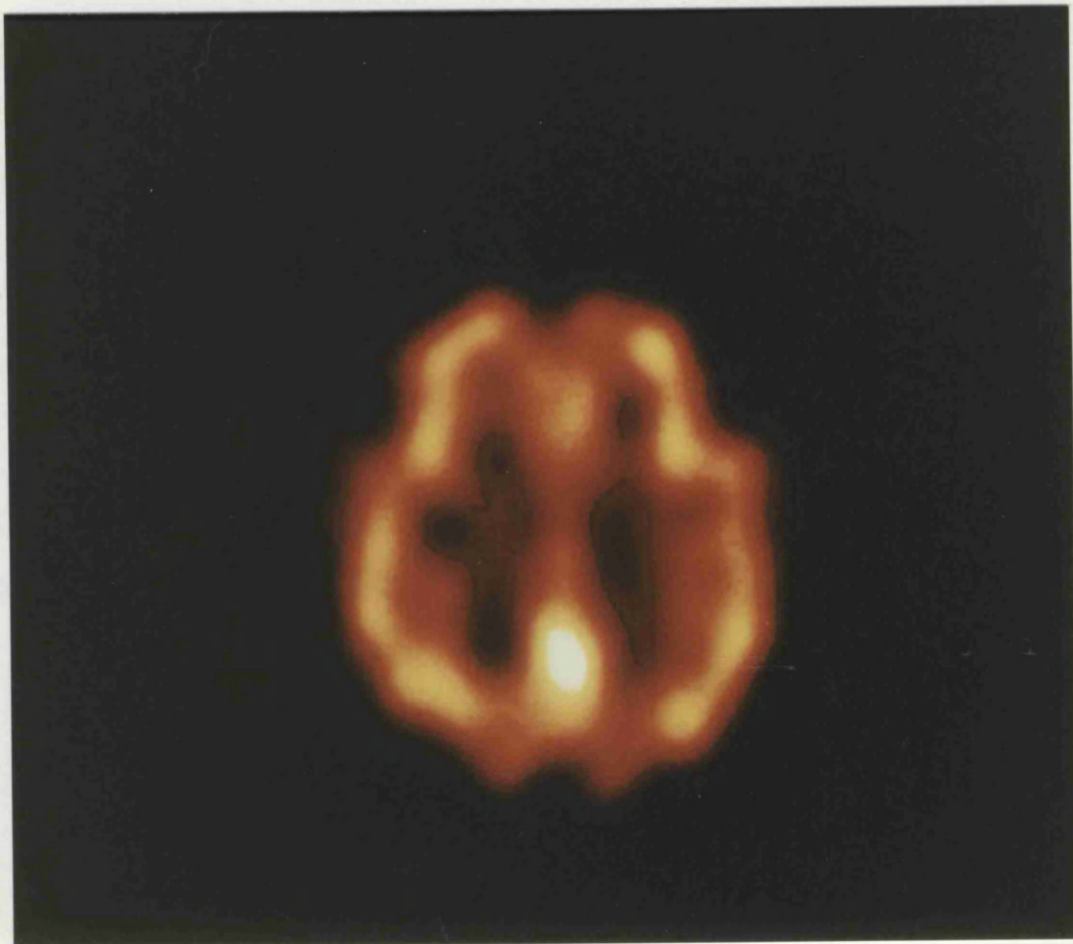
SPECT: Alzheimer's disease
